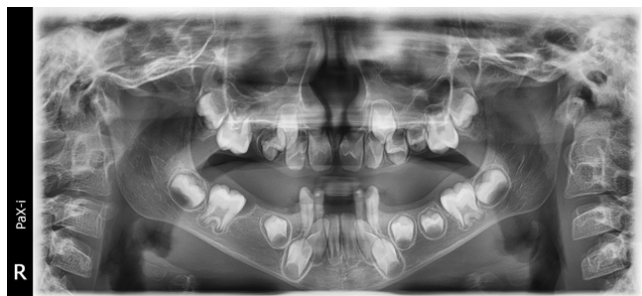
Panoramic X-ray of patient J.G. at the age of 6
